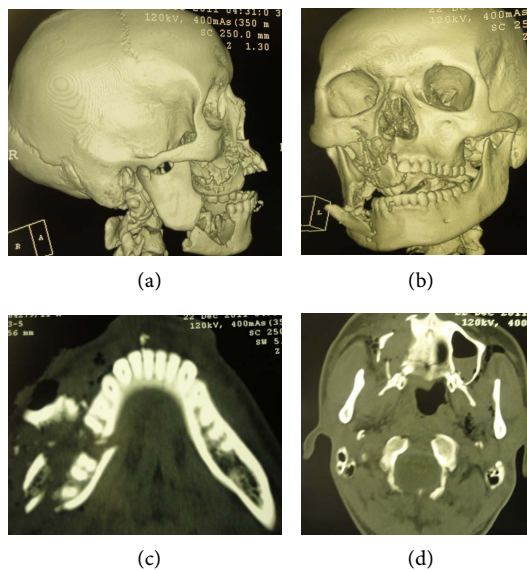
CT scan 3-D images ((a) & (b)) and axial views showing multiple fractures involving the mandible (c) and maxilla (d) with displaced fragments.
